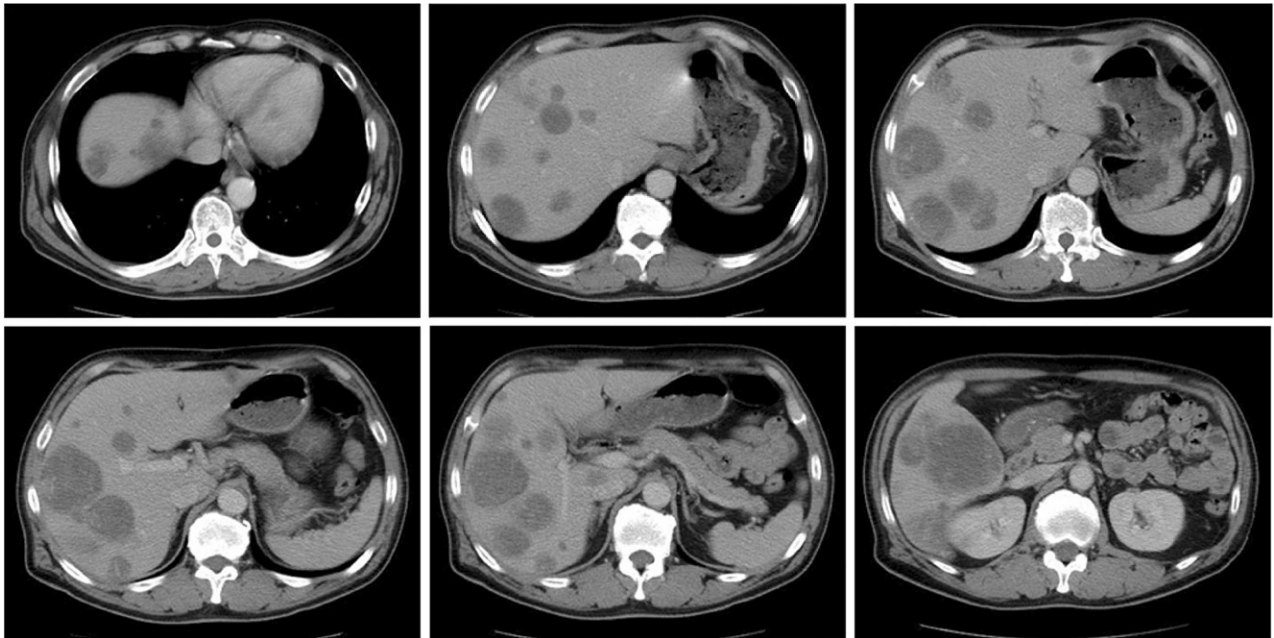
Abdominal computed tomography (CT) scans showed multiple hepatic tumors in the bilobes of the liver. There were more than 40 tumors, the largest of which was 7 cm in diameter.
